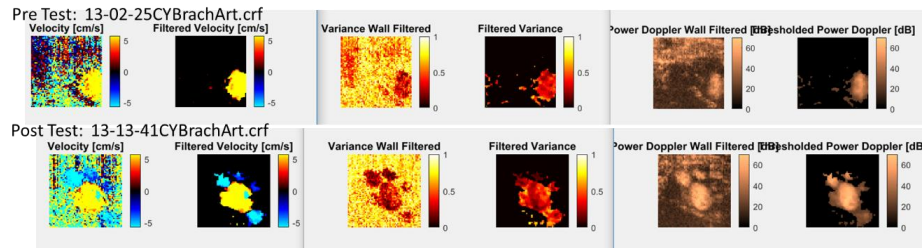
Color Doppler segmented images, read using provided matlab code. (Top row) Baseline images, (bottom row) following exertion images. The velocity, variance and power Doppler can be calculated from the pre scan converted images. The images are shown in sets of two, unfiltered and filtered, in each row, where the filtering is determined by thresholding from number and size of autocorrelation window.
